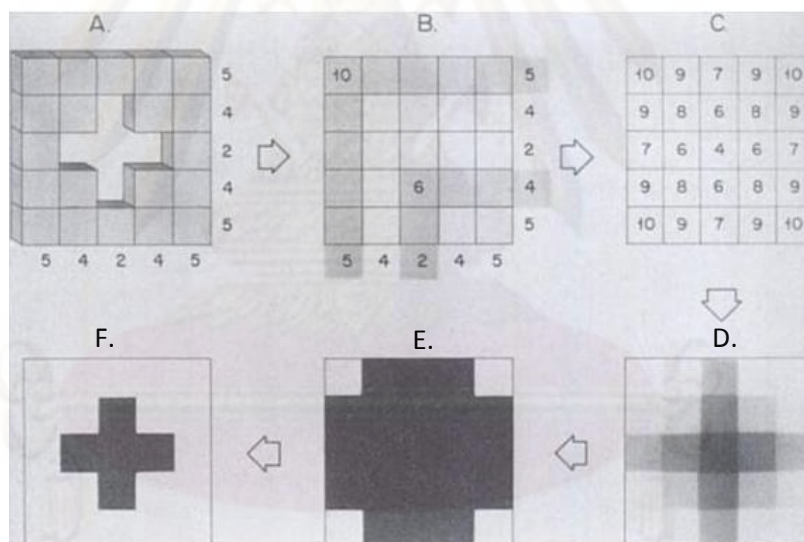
The basic principle of computed tomography. (Curry S Thomas, Dowdey E James and Murry C Robert, Christensen’s Physics of Diagnostic Radiology, Lippincott Williams & Wilkins, 1990)
